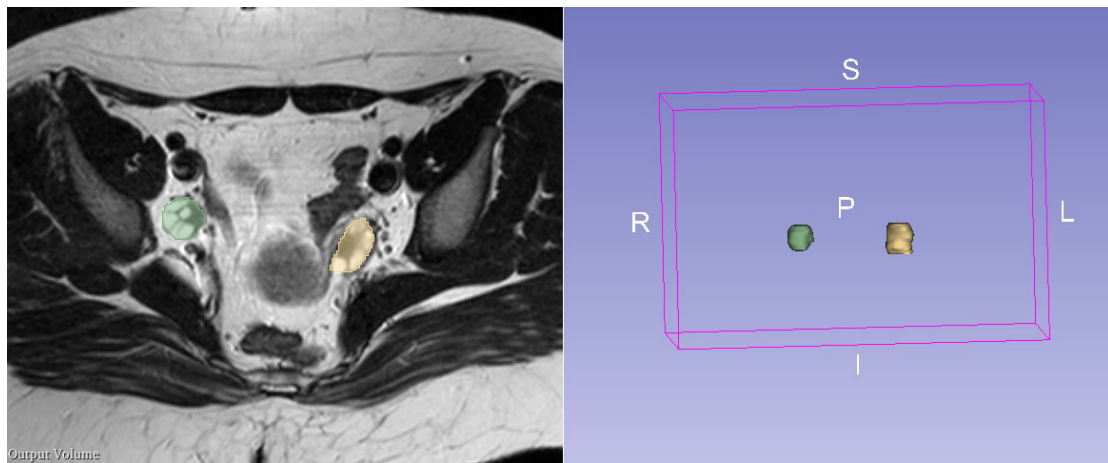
Manual segmentation of the ovary on axial T2-weighted images
